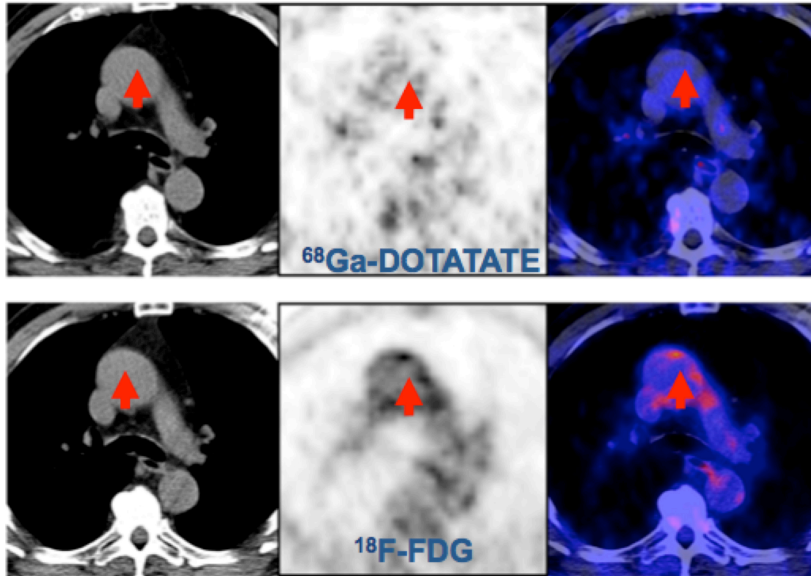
Focal uptake of ^{18}F -FDG but not DOTATATE in the vessel wall. Transverse PET/CT images of a 77-year-old male patient. With hypertension, hypercholesterolemia, history of coronary disease and a family history of cardiovascular disease. Intense ^{18}F -FDG uptake can be observed in the aortic arch (upper row), whereas no focally increased ^{68}Ga -DOTATATE uptake can be seen (lower row). TBRDOTATATE was 1.64, while TRB ^{18}F -FDG was 2.50.
